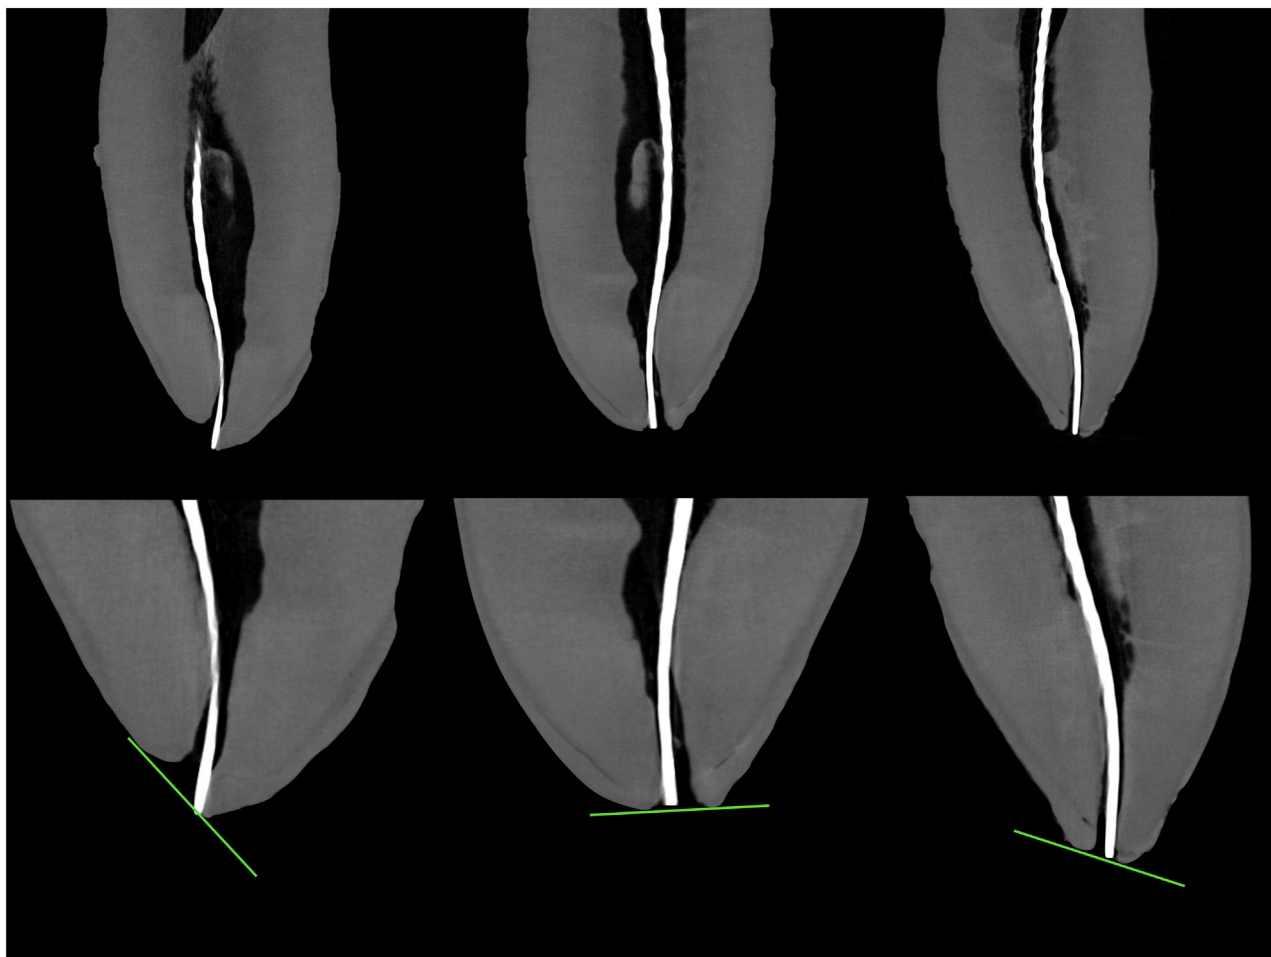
Longitudinal micro-computed tomography cross-sections of the apical third showing the tip of an endodontic file positioned at the “zero” reading mark of the numeric display of the electronic apex locator indicating the position of the major foramen.
